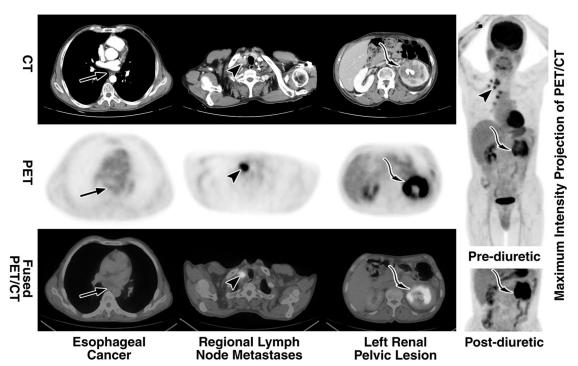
However, neither contrast-enhanced CT nor FDG PET/CT could localize the primary esophageal cancer (arrows pointing to the corresponding location of proven esophageal cancer). This result might be attributed to the well-known, unsatisfactory sensitivity to detect a superficial esophageal cancer with these 2 imaging modalities. In contrast, regional lymph node metastases were easily noted on both CT and FDG PET/CT (arrowheads). Nevertheless, a huge, poorly enhanced, calculus-contained, soft-tissue mass with intense FDG radioactivity (maximum standardized uptake value: 8.8) was present in the left renal pelvis (curved arrows). Although the cytologic examination of urine was negative for malignant cells, renal pelvic malignancy was still highly suspected according to the aforementioned radiologic finding.
